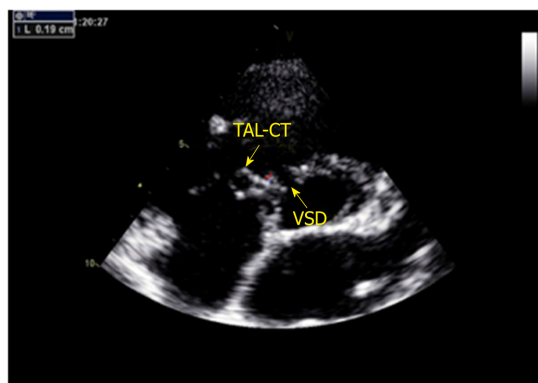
Non-standard aortic short-axis view. The red arrow shows the distance (1.9 mm) from the attachment point of the tricuspid septal leaflet chordae tendineae to the superior edge of the right ventricular side. TSL-CT: Tricuspid septal leaflet chordae tendineae; VSD: Ventricular septal defects.
